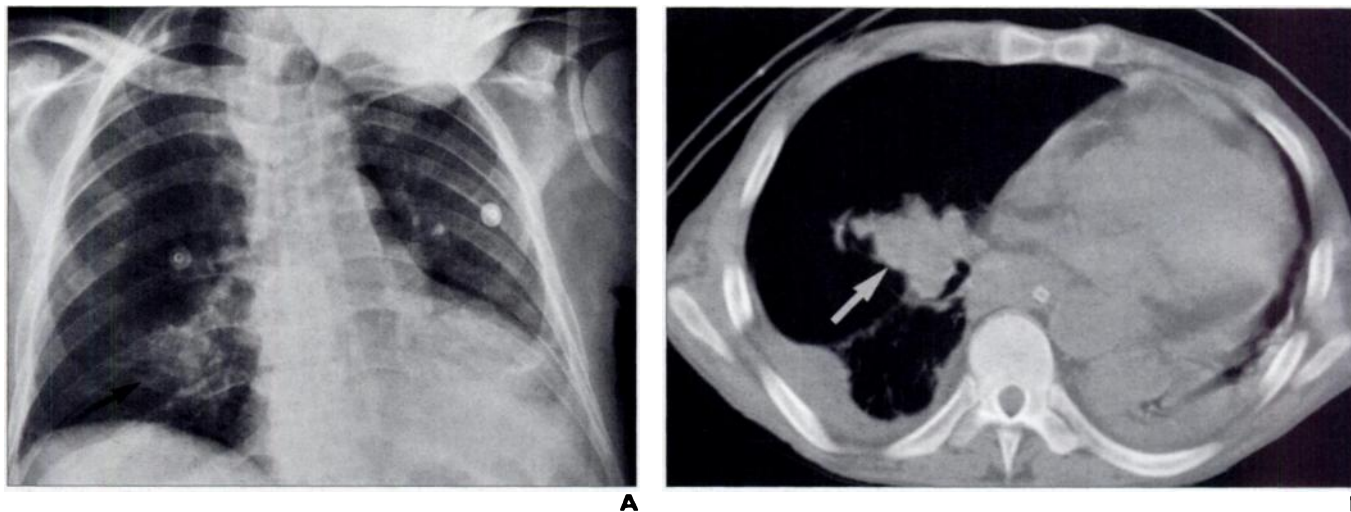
69-year-old man with primary lung carcinoma evident on CT who had nonspecific abnormality on chest radiograph. A, Chest radiograph shows density in right lower lung (arrow) that was initially interpreted as area of atelectasis or pneumonia. Note consolidation at left base. B, CT scan reveals right hilar mass (arrow) that corresponds to area of atelectasis and pneumonia on A. Note consolidation of left lower lobe. At bronchoscopy (not shown), mass proved to be lung carcinoma. Consolidation of left lower lobe was presumed due to aspiration pneumonia.
